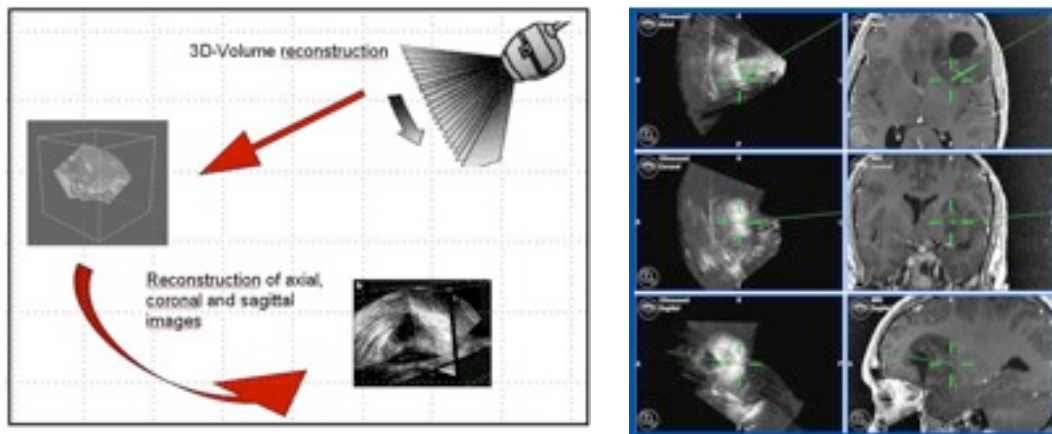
(left) The Navigated 3D ultrasound combines acquired 3D volumes with the preoperative MRI/CT data sets and displays ultrasound images in familiar planes (axial, coronar, sagittal) (Fig. 7 left) next to their corresponding MRI images (Fig. 7 right).
